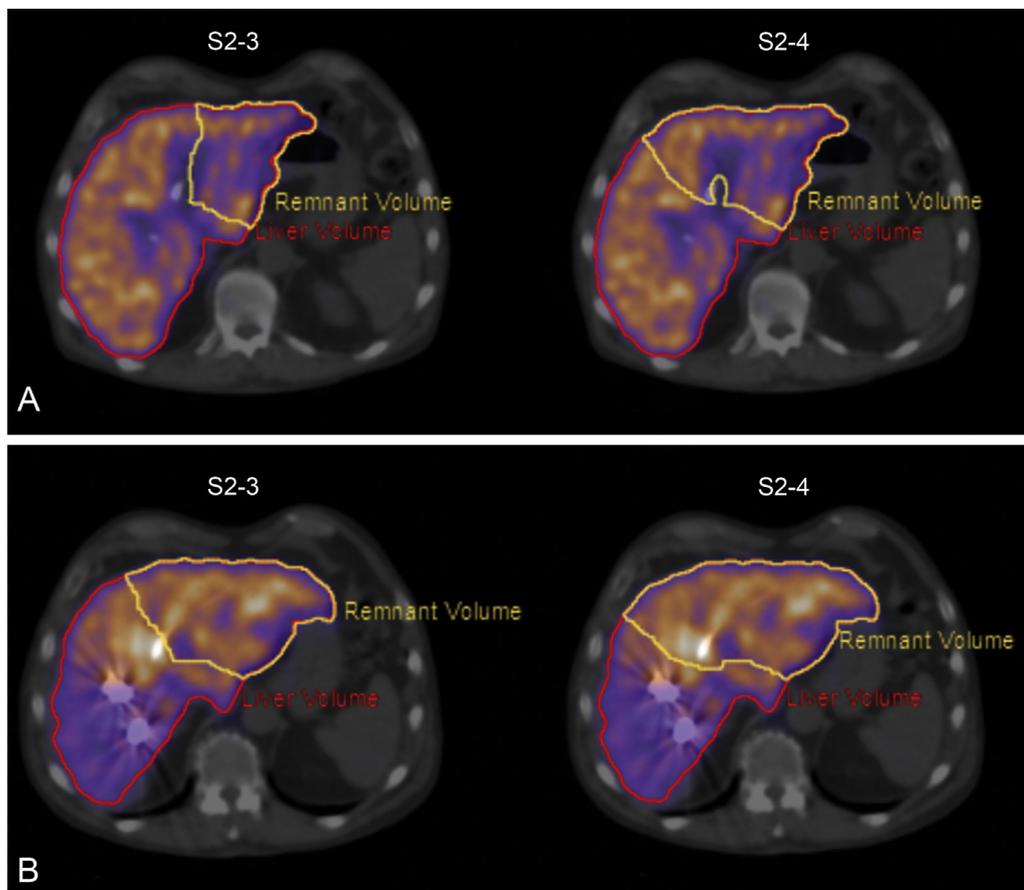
SPECT delineation of S2-3 + S2-4 (A) pre-PVE and (B) post-PVE.
